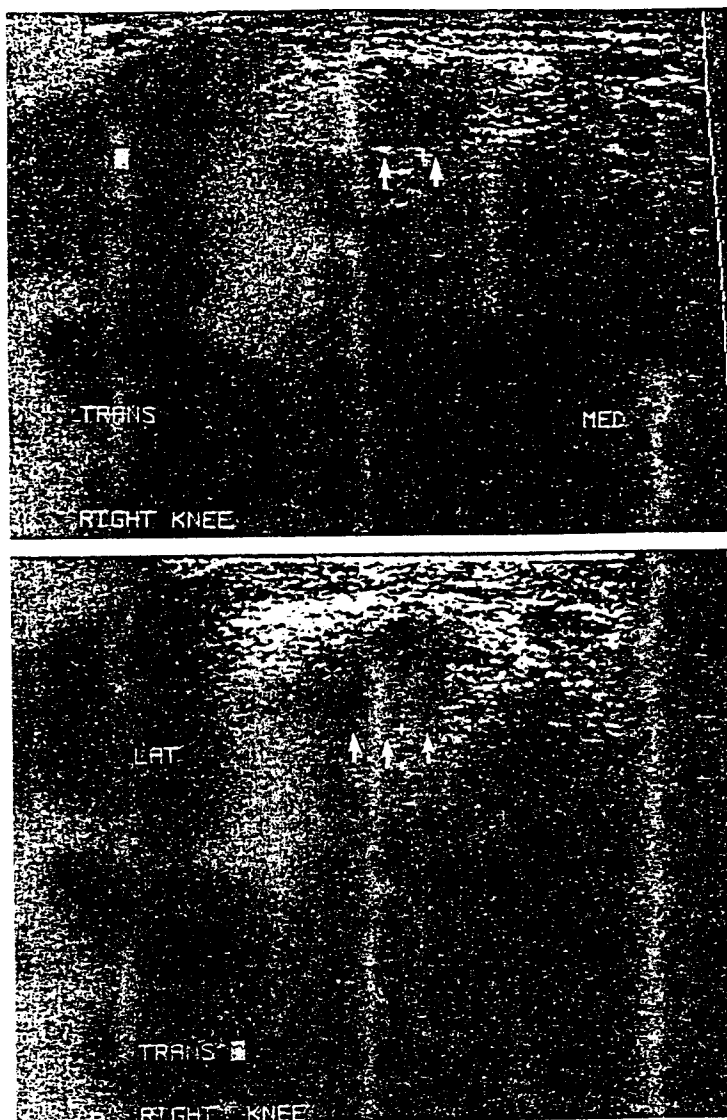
Axial sonographic studies conducted 14 months apart of a competitive 31-year-old basketball player with symptomatic jumper's knee reveal unchanged cross-sectional area of a hypoechoic region of the right patellar tendon despite full training and competition ( $7.3 \times 5.4$  mm at baseline and  $7.4 \times 6.7$  mm at follow-up). x-x, width; +- = height.
